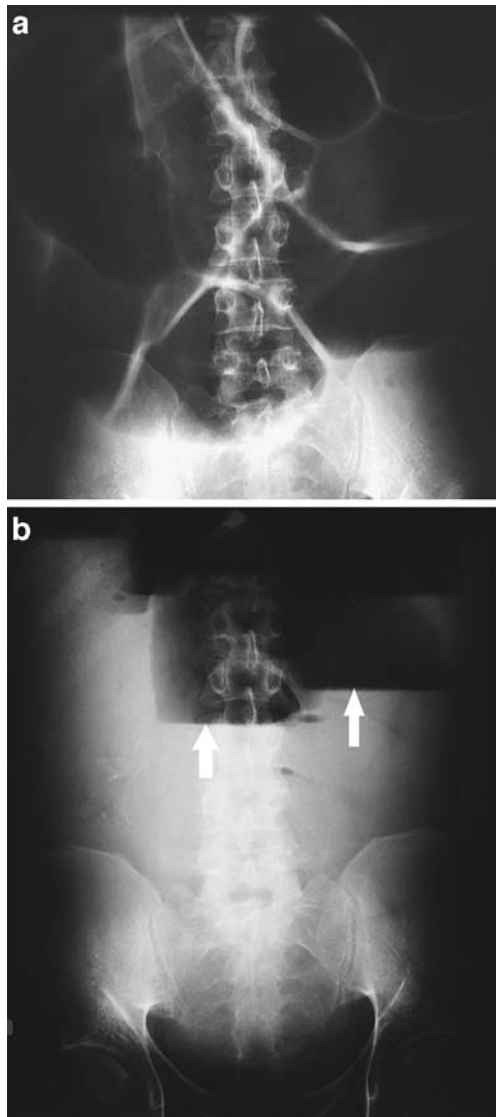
A 19-year-old man with a known myogenic form of CIPO and prior history of colectomy followed by distal ileostomy. The patient was admitted for routine nutritional evaluation. a Abdominal plain radiograph performed in supine position shows multiple distended bowel loops. b Abdominal plain radiograph performed in upright position shows air-fluid levels (arrows) within distended bowel loops
